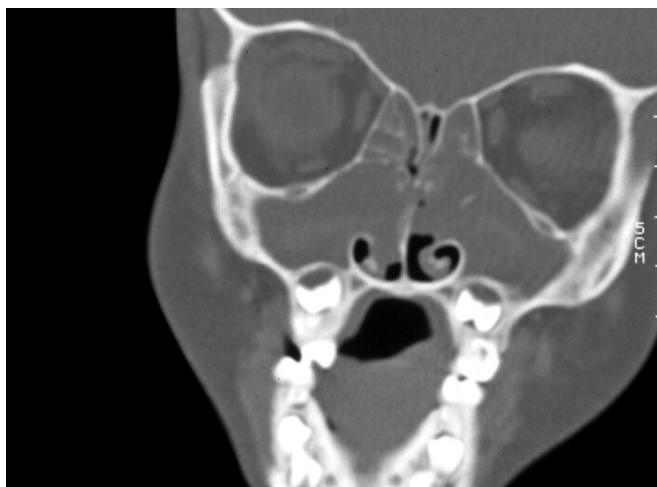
Coronal CT in cystic fibrosis patient with classic findings of extensive nasal polypsis.
